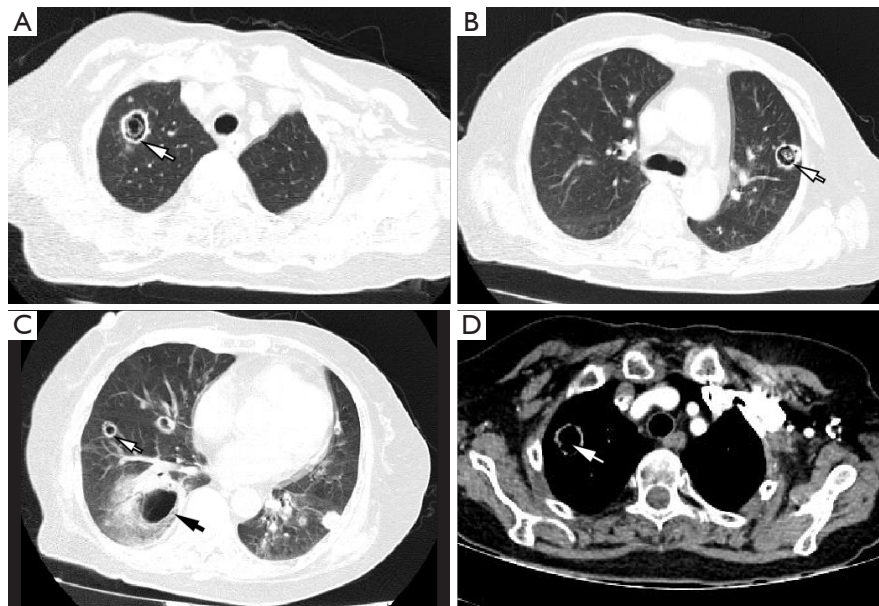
CT of diabetic patient with chronic cavitary pulmonary aspergillosis (female, 73 years old). (A-C) There are multiple thick-walled cavities and nodular shadows of different sizes in both lungs. (A) There is a cavity in the upper lobe of the right lung, with annular slightly low-density shadows seen inside. Small nodules and a few patchy GGO shadows are seen around this cavity (white arrow); (B) irregular air-containing nodular shadows (white arrow) are seen inside the cavity in the upper lobe of the left lung; (C) there are multiple cavities here (white arrow, black arrow), with the larger one located in the right lower lung (black arrow), its inner wall is smooth, and halo sign is seen around the cavity (black arrow); (D) the cavity wall is slightly enhanced on the enhanced scan (white arrow). CT, computed tomography; GGO, ground glass opacity.
